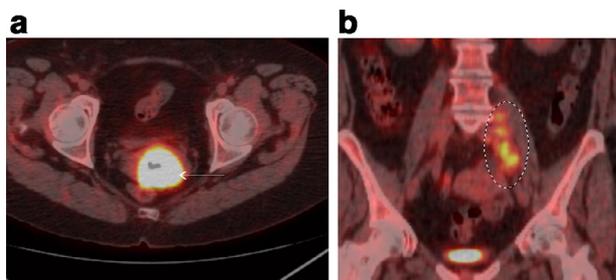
(a) FDG-PET/CT of cervical tumor. (b) PET/CT revealed left iliac lymphadenopathy.
